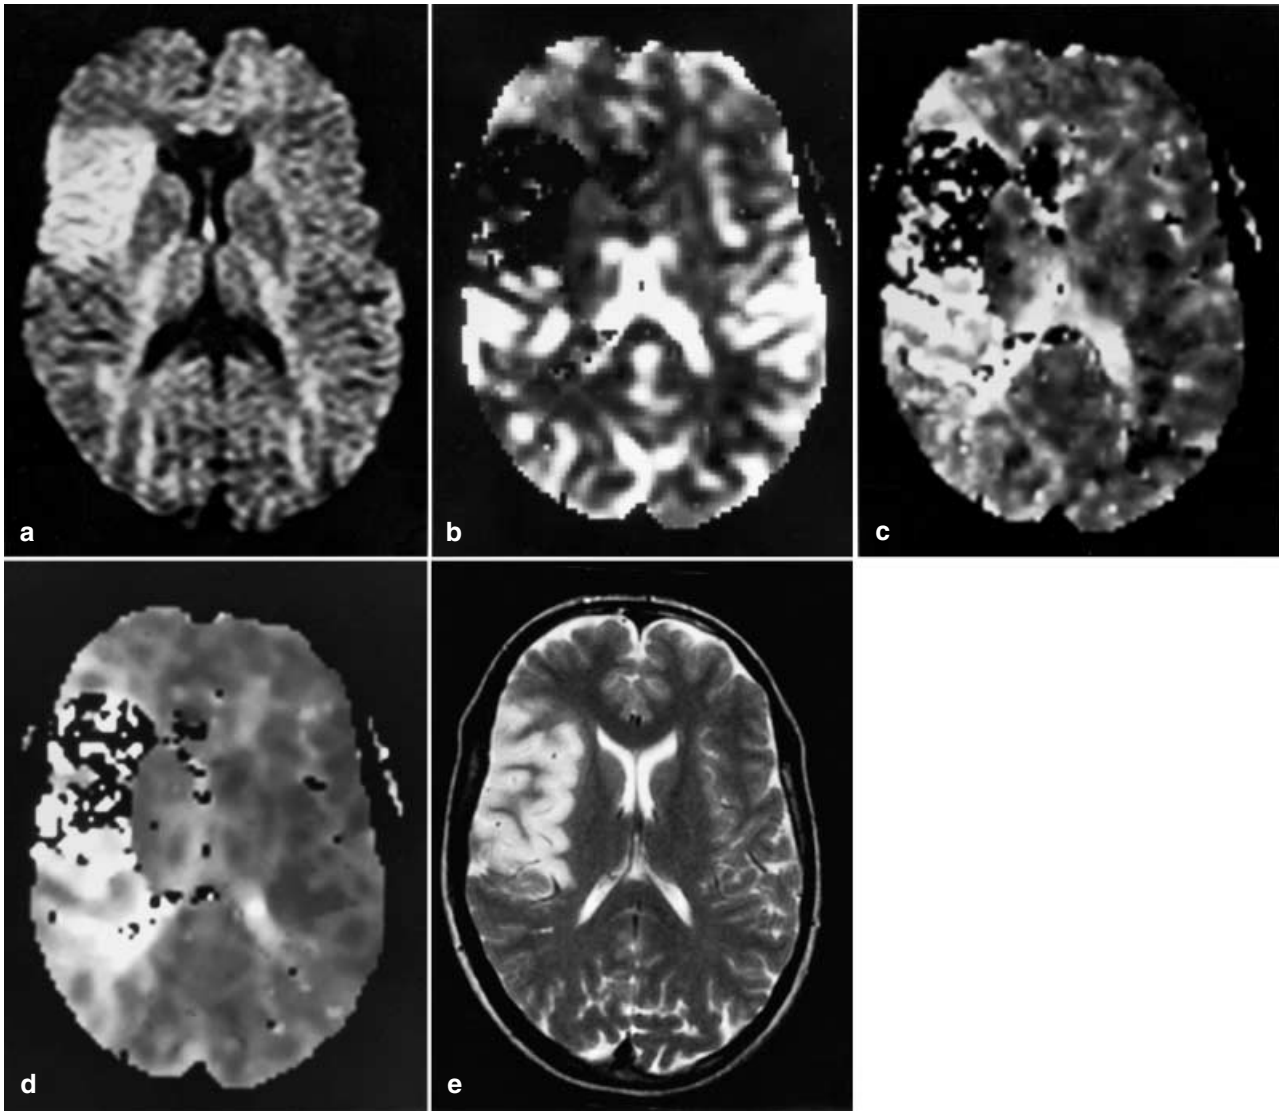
32-Year old patient with left sided hemiplegia since 120 minutes. Initial DWI (a) already show a partial MCA infarction. Correspondingly, initial perfusion parameter maps (b–d) show a perfusion deficit in the infarcted area. The surrounding area was marked by an increased rCBV (b) and a significant delay on MTT (c) and TTP (d) maps. On first follow-up examination (e) 24 hours later, the infarct had already grown into these areas
